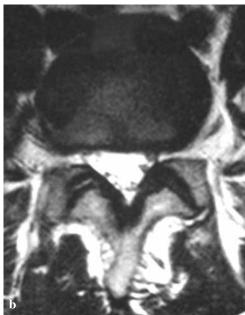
T2 weighted MRI of the spine showing modest disc degeneration at the L4/5 level with a central disc bulge without evidence of neural compression in (a) sagittal, (b) axial views.
